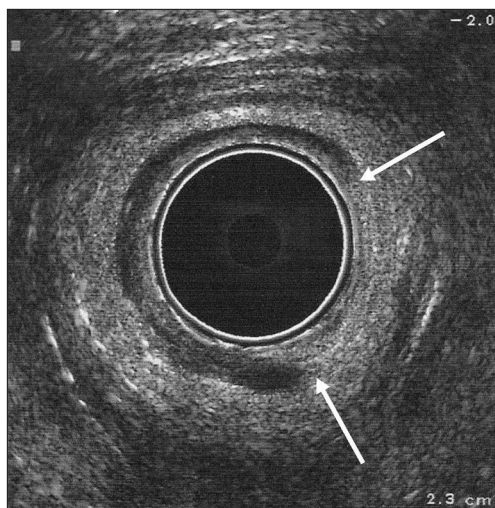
Endoanal ultrasound showing a combined internal and external anal sphincter defect between white arrows at 10 and 1 o'clock.
